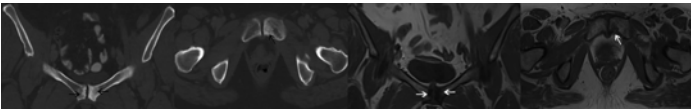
Coronal and axial CT of the pelvis demonstrate diffuse subchondral sclerosis (*black arrows*) of the pubic symphysis. Corresponding coronal and axial T1-weighted MR demonstrate focal hypointensity (*white arrows*), consistent with osteitis pubis.
